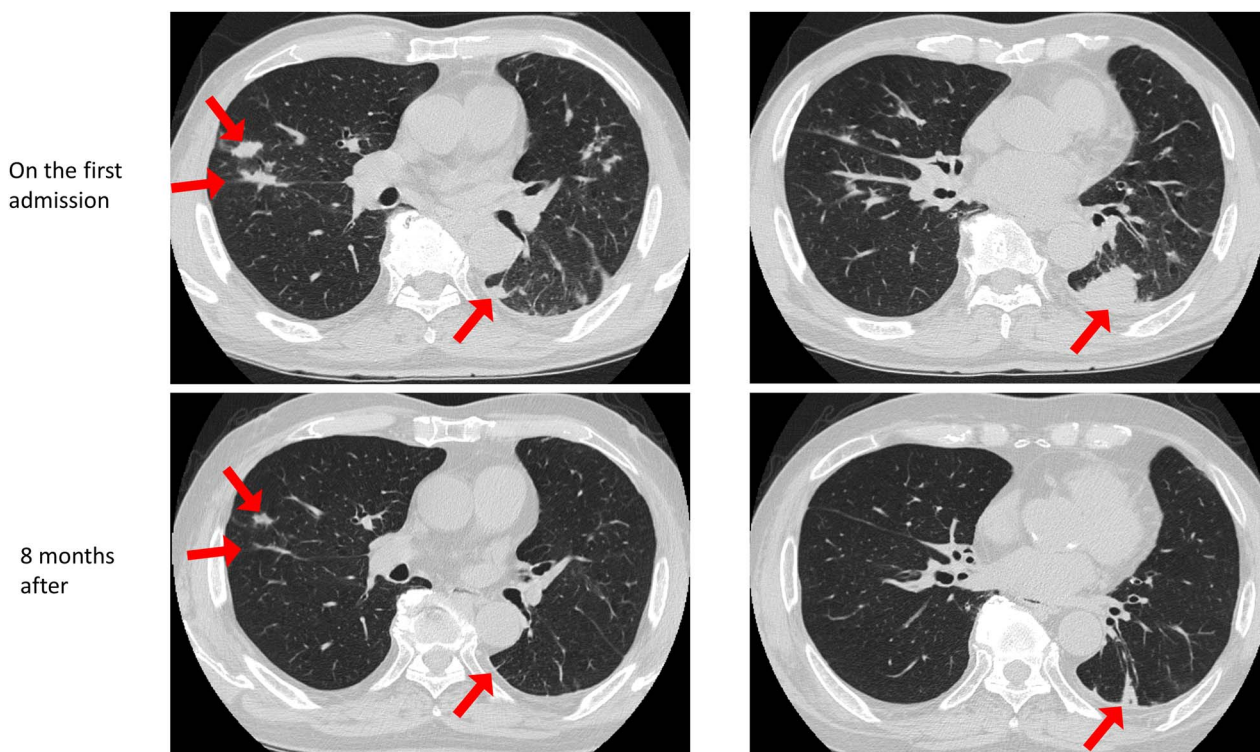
Chest CT showing multiple pulmonary nodules (red arrows) on the first admission (a). The pulmonary nodules decreased in size (b), 8 months after rheumatoid arthritis treatment.
